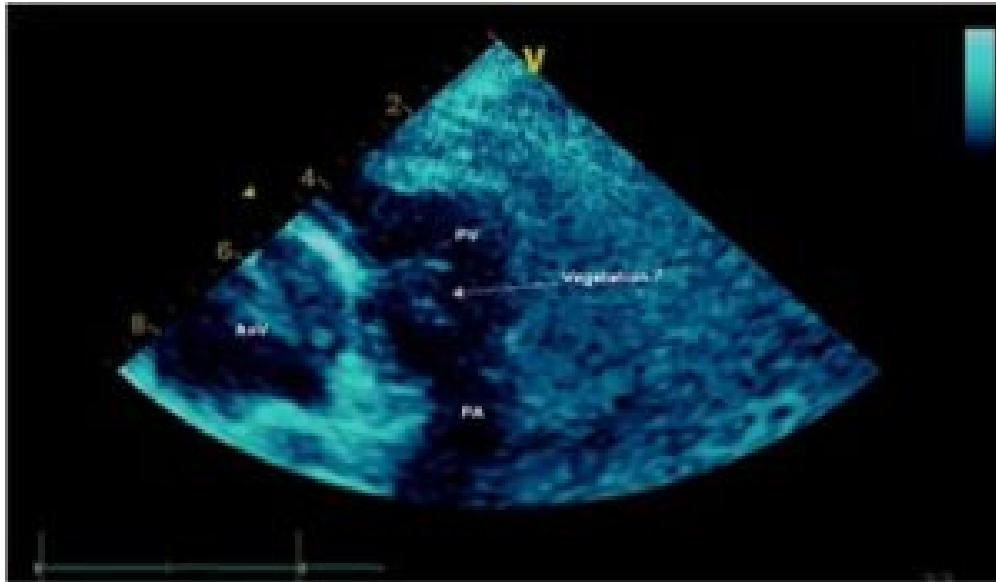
Suggestive vegetation in pulmonary valve due to erratic structure seen through transthoracic echocardiogram. “AoV, aortic valve; PA, pulmonary artery; PV, pulmonary valve.”¹
